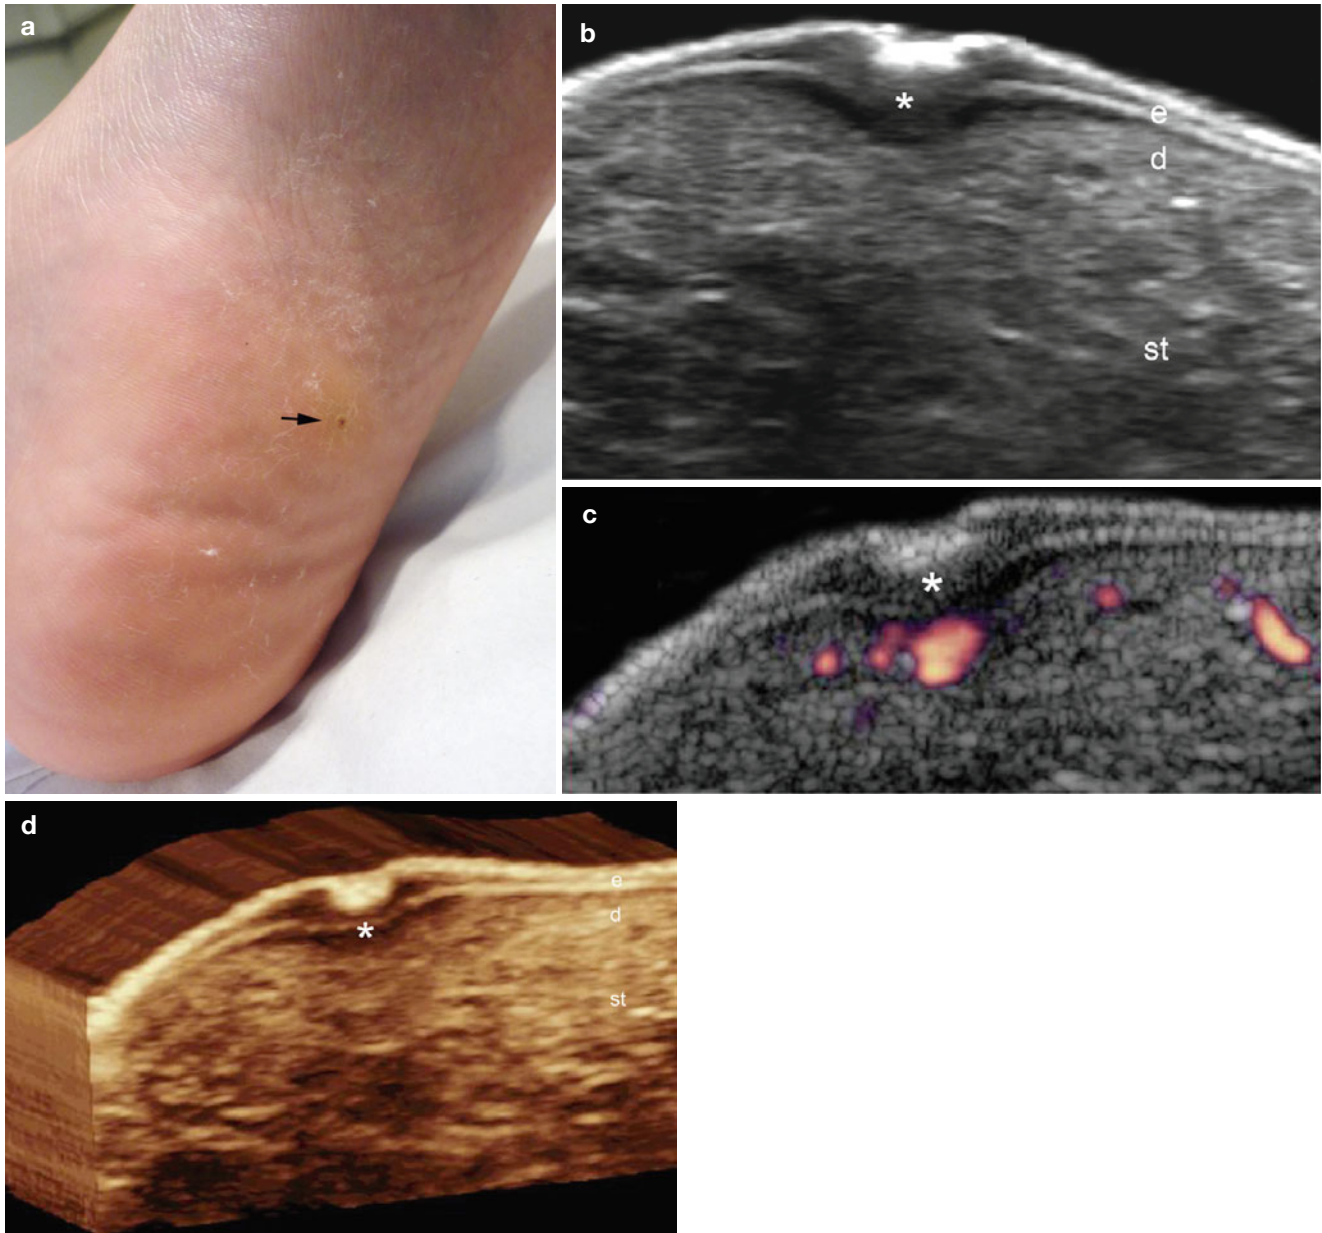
(a–d) Plantar wart. (a) Clinical image shows hyperkeratotic lesion in the sole of the left foot. (b) Gray scale ultrasound image (transverse view) demonstrates fusiform shaped hypoechoic structure (*) that involves epidermis and dermis. The central hyperechoic epidermal
